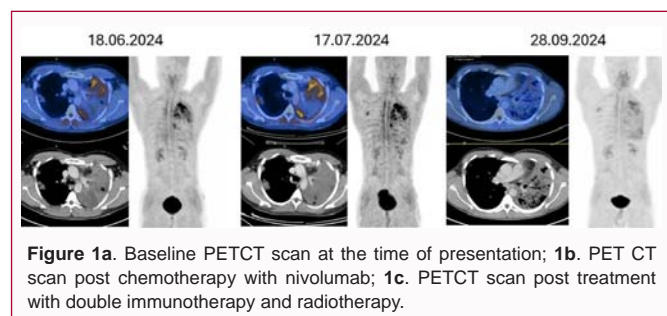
Baseline PETCT scan at the time of presentation; 1b. PET CT scan post chemotherapy with nivolumab; 1c. PETCT scan post treatment with double immunotherapy and radiotherapy.
